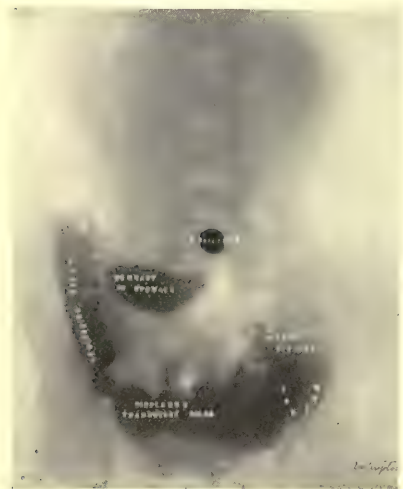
Shows marked enteroptosis (prolapse of large intestine. Radiograph by Tousey). Six-hour residue in stomach. (Same case.)
